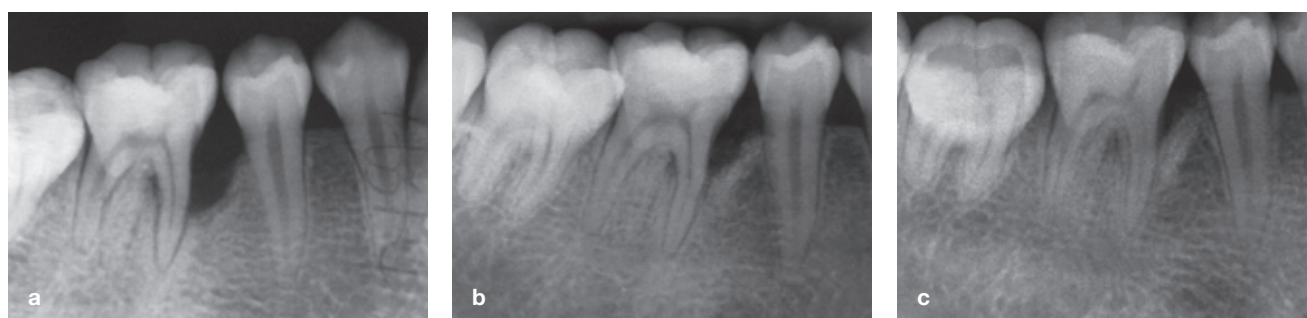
Long-cone paralleling technique. a) Radiograph of the right mandibular first molar before first surgery. b) Radiograph at 6 months after the first surgical bone graft procedure. c) Radiograph at 6 months after the second surgical bone graft and GTR procedure. Compared with the original situation (a), pronounced new bone formation mesial of the tooth can be observed.
